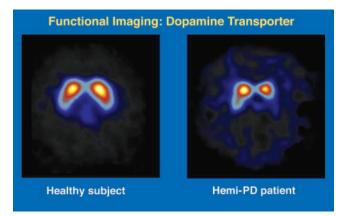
SPECT 123I-( $2\beta$ -carboxymethoxy- $3\beta$ (4-iodophenyl)tropane) images of a healthy subject and an early PD patient with symptoms only on the right side. The loss of activity in the PD patient is asymmetric, but there is a bilateral reduction in activity in the basal ganglia. Levels of SPECT activity are color-encoded from low (black) to high (yellow/white). (Figure courtesy of J. Seibyl, Institute for Neurodegenerative Disorders.)
